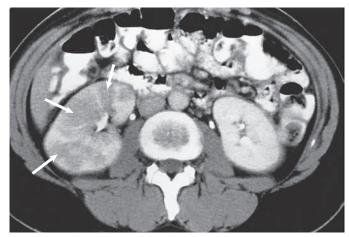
Acute pyelonephritis. Contrast-enhanced CT scan shows areas of lower density caused by infection and edema *(arrows)*. (Courtesy W. Bush, University of Washington, Seattle, Wash.)
